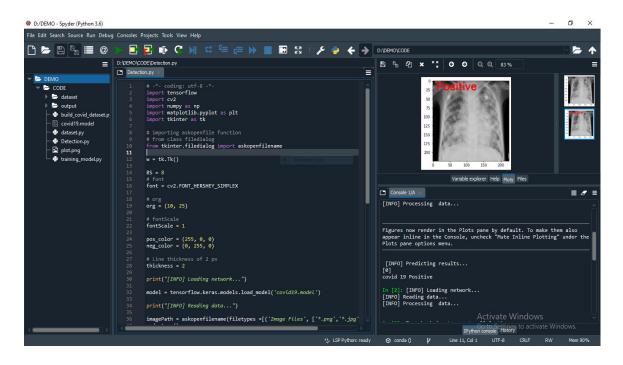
testing –Xray images (Positive)
